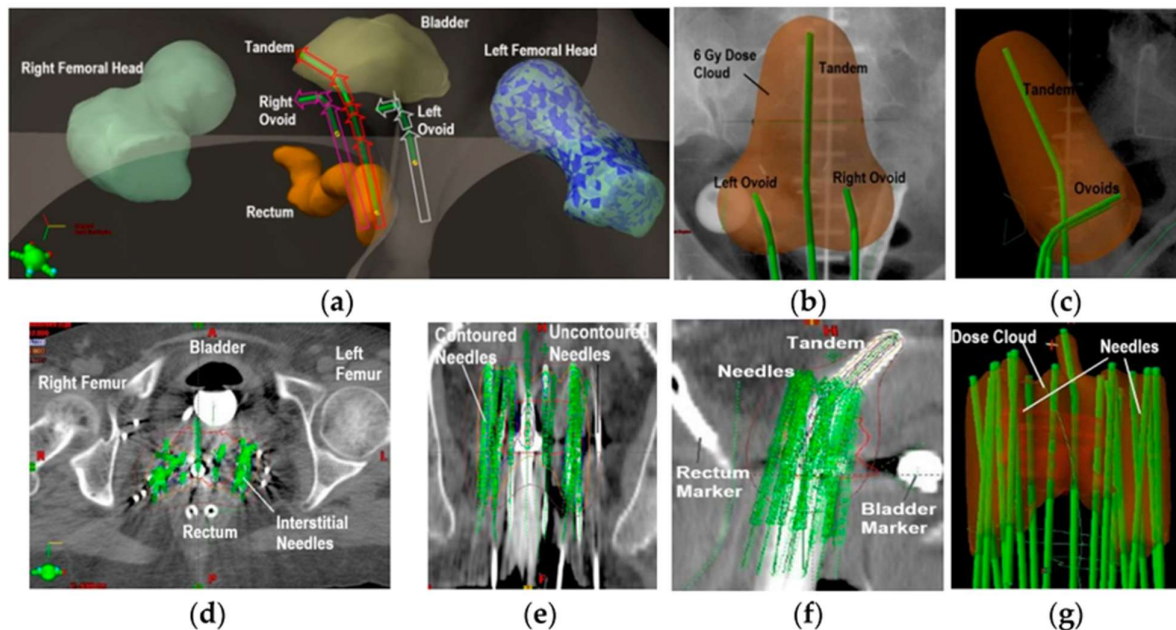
CT-based 3D rendering of tandem-and-ovoids brachytherapy showing applicators, OARs, and isodose coverage. A real-patient CT-based rendering with applicator geometry, dwell positions, and isodose contours. Fantastic for demonstrating how planning translates into real anatomy. Reproduced from Roa D E, Kuo J, Moyses H, et al. *Fiber-Optic Based Laser Wakefield Accelerated Electron Beams and Potential Applications in Radiotherapy Cancer Treatments* (2022). Image used courtesy of the authors / via ResearchGate.
